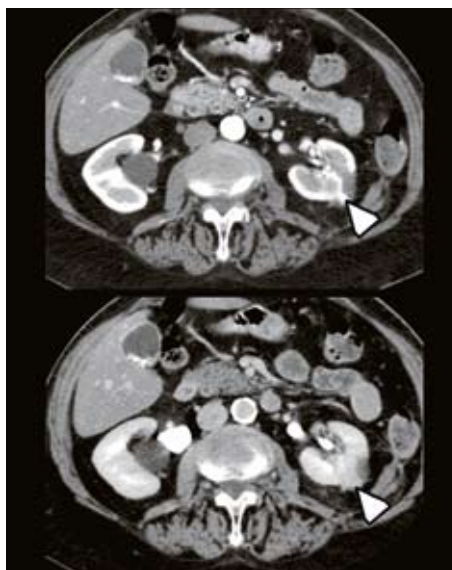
d and e: Contrast-enhanced CT performed at six weeks (immediately before the second RFA session) confirmed the diagnosis of 2 renal tumor residues at the upper anterior part of the ablated area (Fig. 5 d) and lower posterior part of the ablated area (Fig. 5 e).
